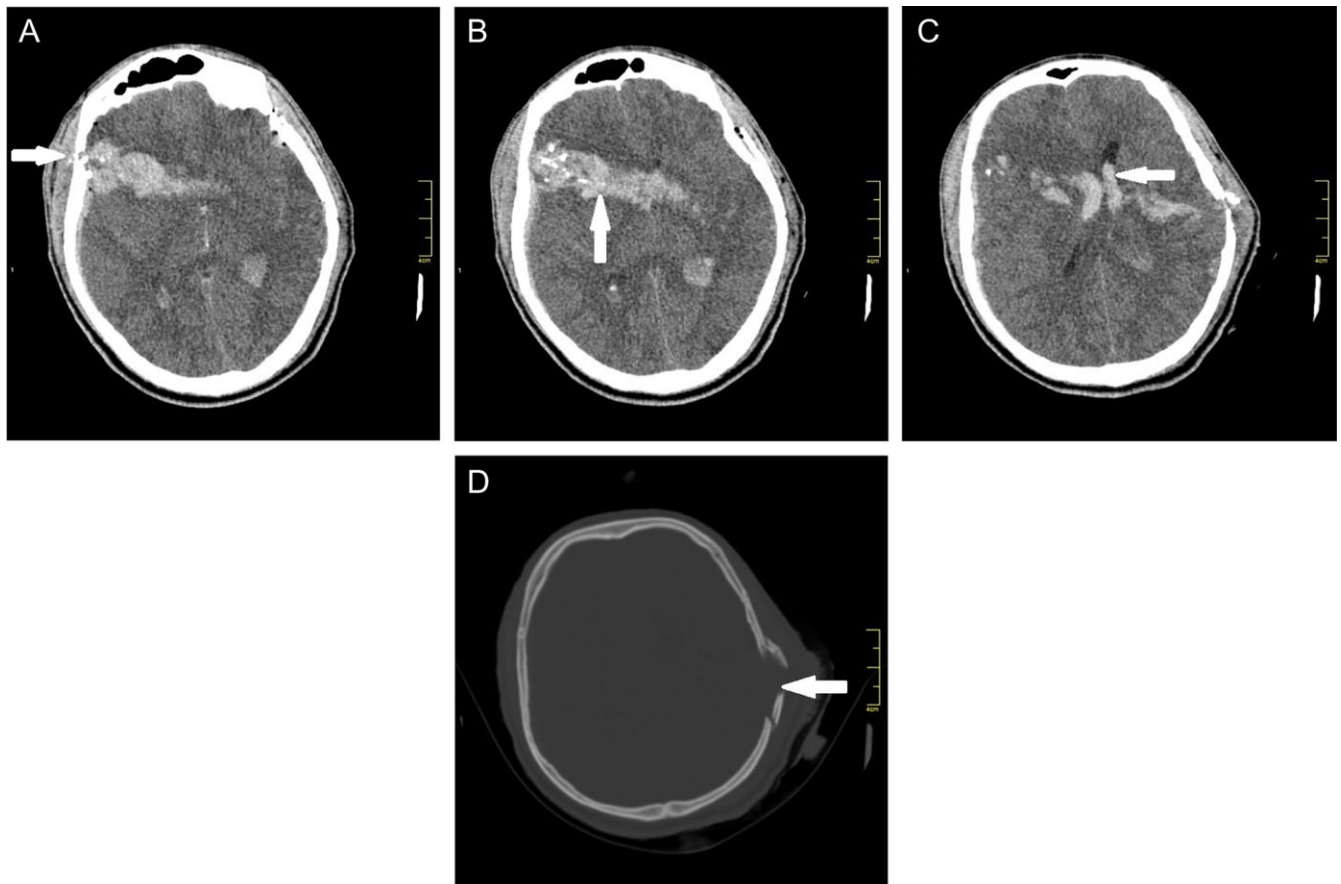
Brain computed tomography (CT) showing (A) inlet (white arrow) in the right temporal bone, (B) wound channel filled with blood and bone fragments (white arrow), (C) intraventricular hemorrhage (white arrow), and (D) explosive fracture of skull base near the outlet.
